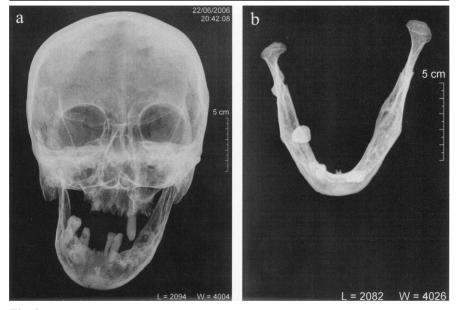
Antero-posterior projection of the skull showing evident asymmetry of the facial skeleton at the level of the nasal and maxillary bones, which appear larger on the left side: (a); marked hypoplasia of the right hemi-mandible corpus of the mandible, visible on x-ray (b).
